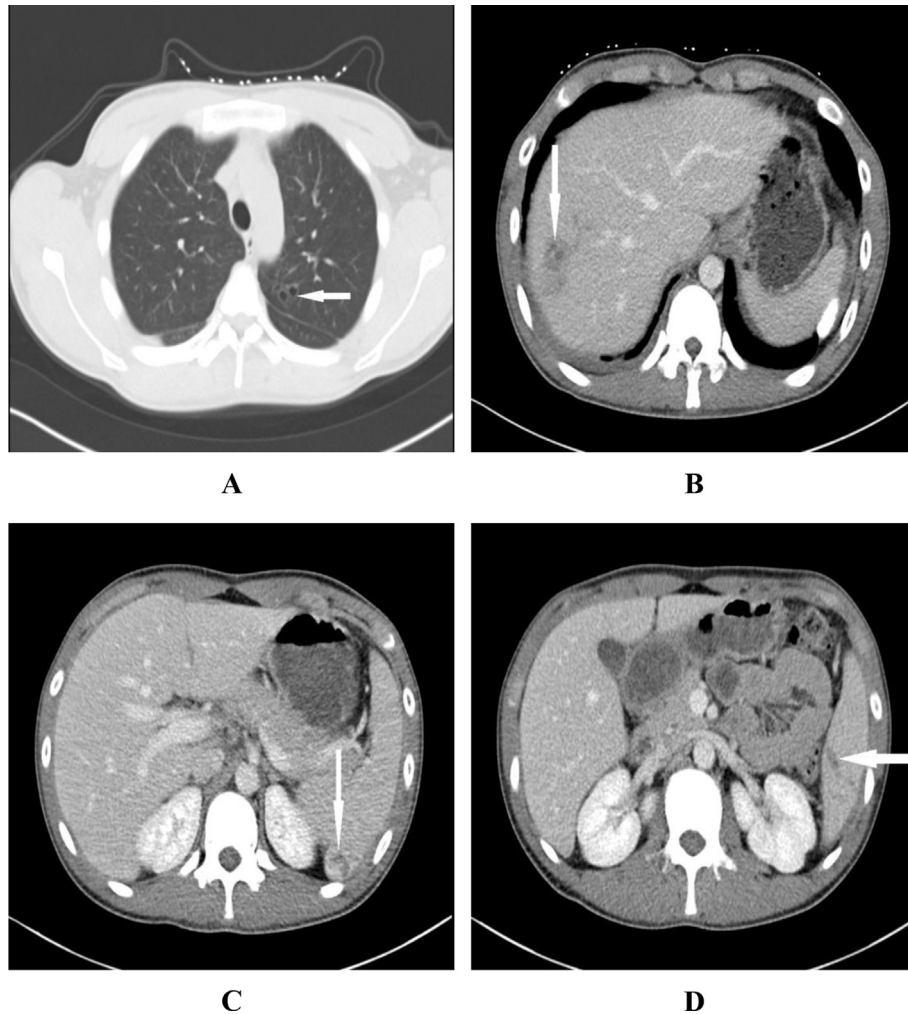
A 21-year-old man with both pulmonary and abdominal paragonimiasis. Plain CT scan of chest shows multiple thin-walled cystic lesions consisting fluid or gas (worm cysts) (arrow) (A). Contrast-enhanced CT scan of abdomen at portal venous phase shows conglomerated small cystic or serpentine lesions and tubular low-attenuated lesions (migration track) in the right lobe of liver (arrow) (B) and spleen (arrows) (C, D).
